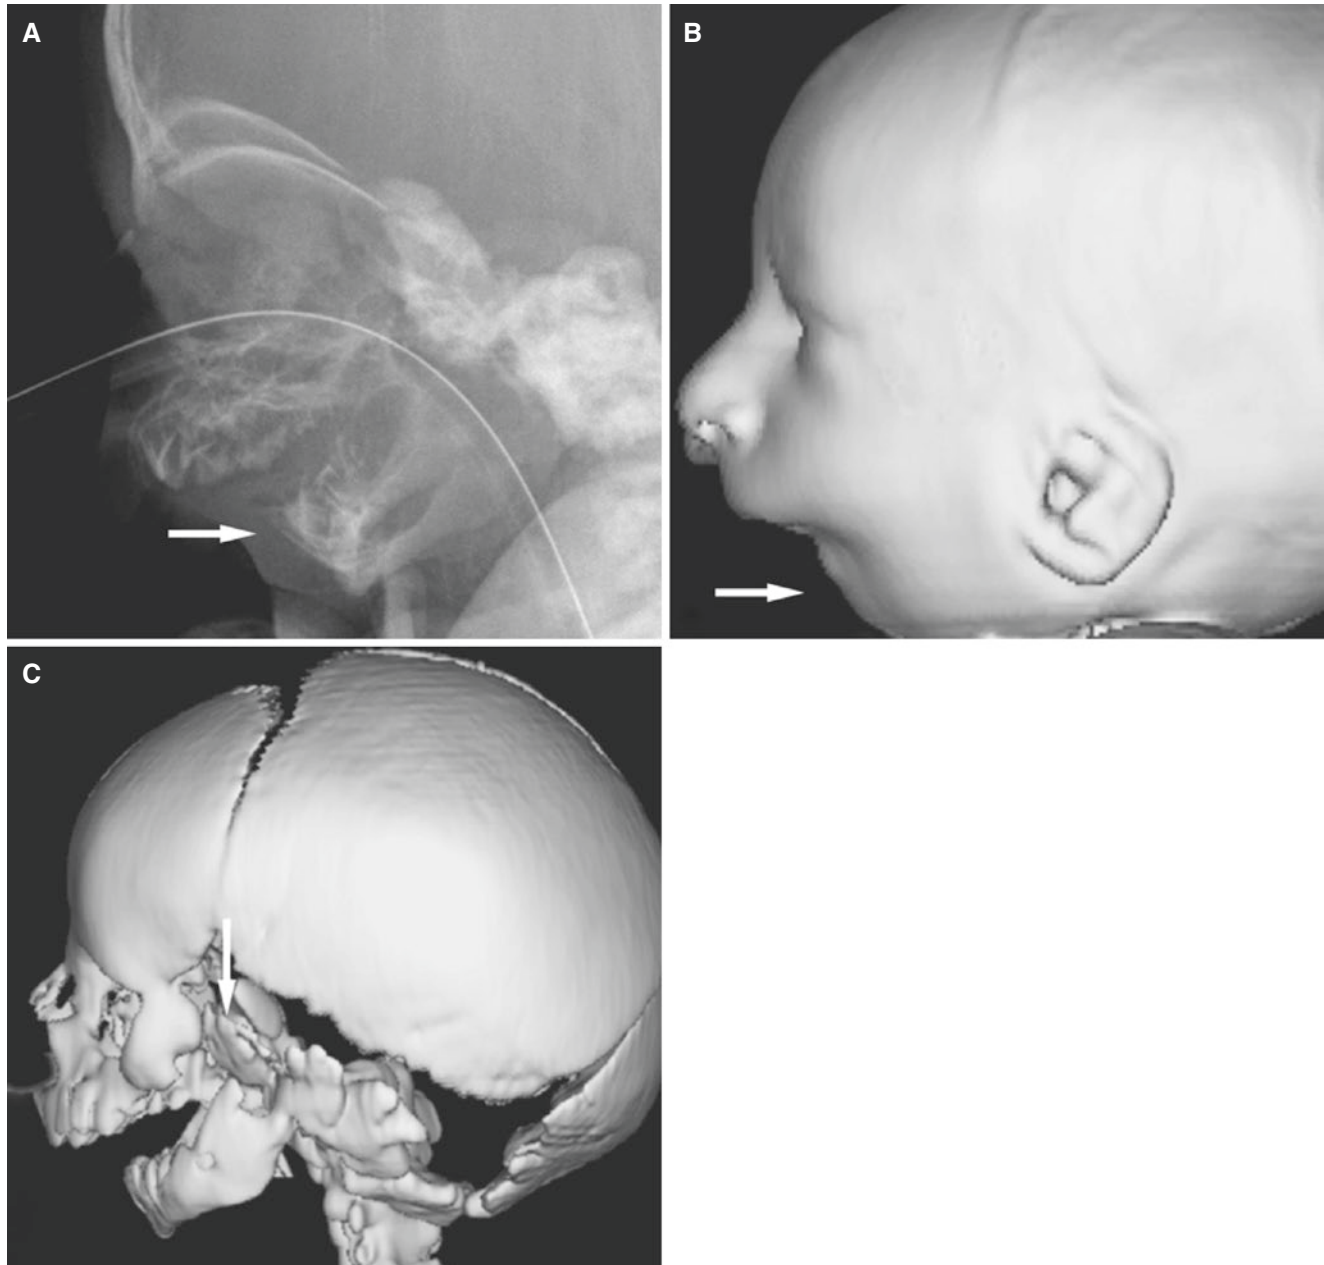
Treacher Collins syndrome; newborn with respiratory distress. (A) Lateral view shows very small and retruded mandible (*arrow*) and airway tube. (B) 3D CT image of the skin, lateral view, shows
